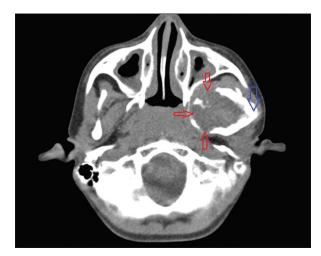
Computed tomography scan showing a osteolytic and osteosclerotic lesion of 5×3 cm with cortical expansion on lateral side with three areas of cortical perforation on medial side with intra lesional calcifications
